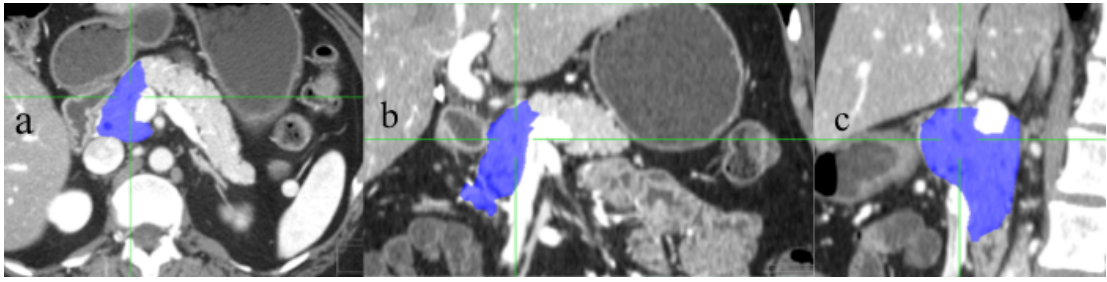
Measurement of the PVR of the head of the pancreas in Study II. Computed tomography of the pancreas showing 3D segmentation and volume calculation (blue color) in (a) transverse, (b) coronal and (c) sagittal images.
